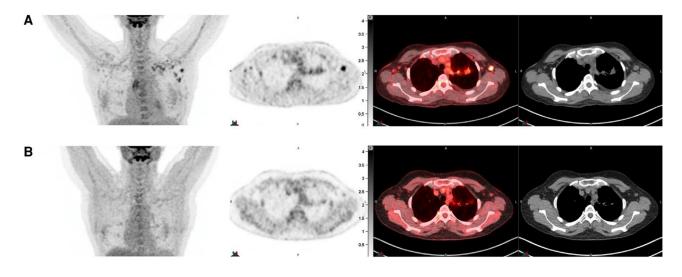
Improvement of *Paecilomyces variottii* pneumonia with posaconazole treatment. Shown are representative positron emission tomography (PET)/computed tomography (CT) images of the patient's chest with fluorodeoxyglucose avidity mapped. *A*, Coronal maximum intensity projection image, axial PET, PET/CT overlay, and axial CT scan from left to right, about 1 week after switching therapy from itraconazole to posaconazole. *B*, The same sequence of images 6 months later at the time of the sixth cycle of cyclophosphamide.
